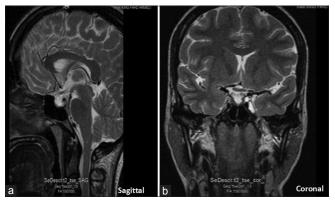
(a) Coronal section of pituitary magnetic resonance imaging showing empty sella with no obvious pituitary gland tissue. (b) High signal T2 sagittal section of same pituitary showing empty sella.
